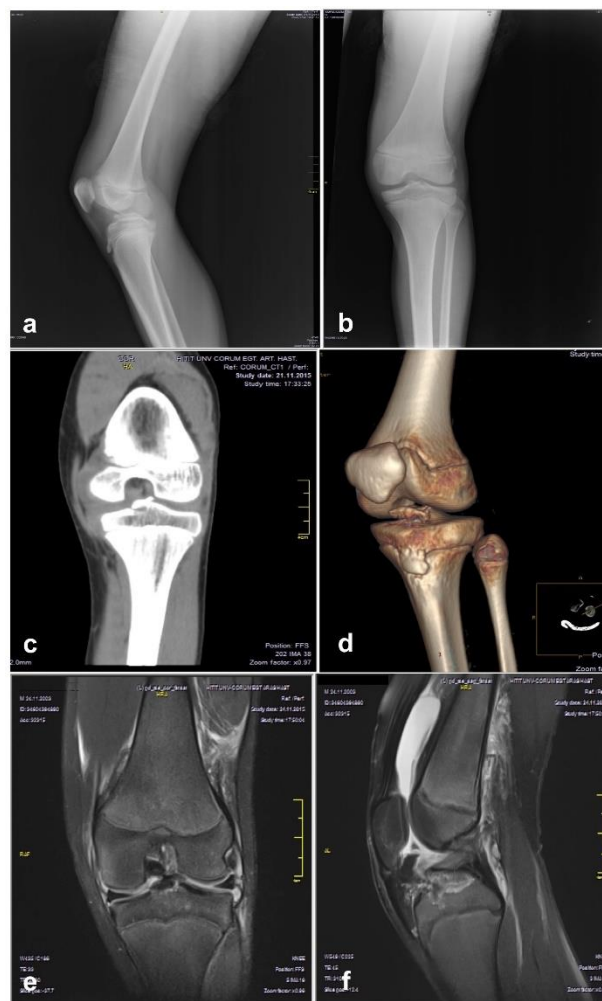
Preoperative radiologic images of 12-year old male patient with Type IIIA tibial intercondylar eminence fracture. a, lateral X-ray image; b, anteroposterior X-ray image; c, coronal CT image; d, three-dimensional CT image; e, coronal MR image; f, sagittal MR image.
